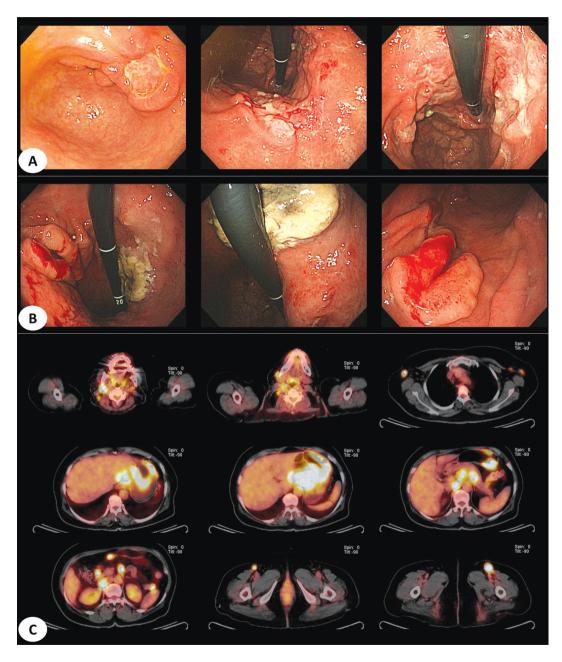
Two cases of mixed type with two or more endoscopic findings. (A) Primary DLBLC. (B) Secondary DLBLC. (C) Hypermetabolism of stomach and multiple distant lymph node was seen on PET-CT in cases of B (Abbreviation. DLBCL, diffuse large B-cell lymphoma; PET-CT, positron emission tomography-computed tomography).
